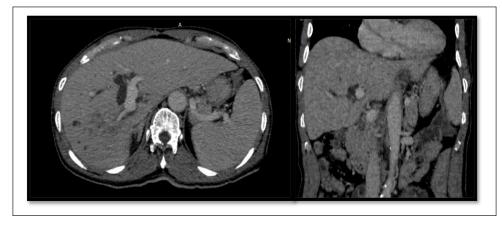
CT liver-depicting mass forming hilar tumour with right lobar atrophy and right portal vein thrombosis and central intrahepatic biliary dilatation.
